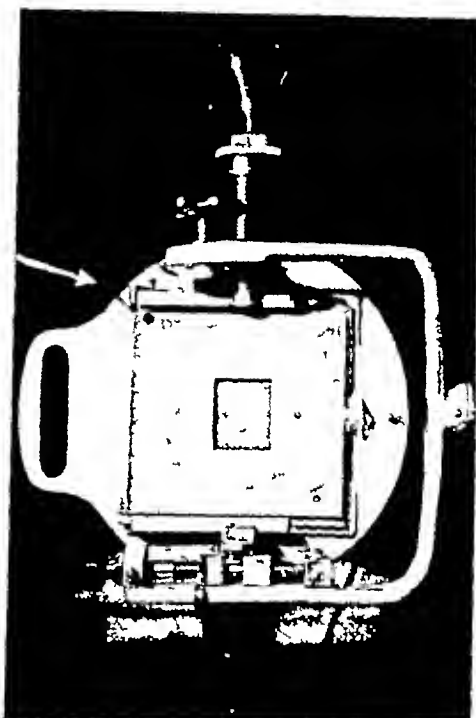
Diaphragm for chest roentgenography mounted in position
